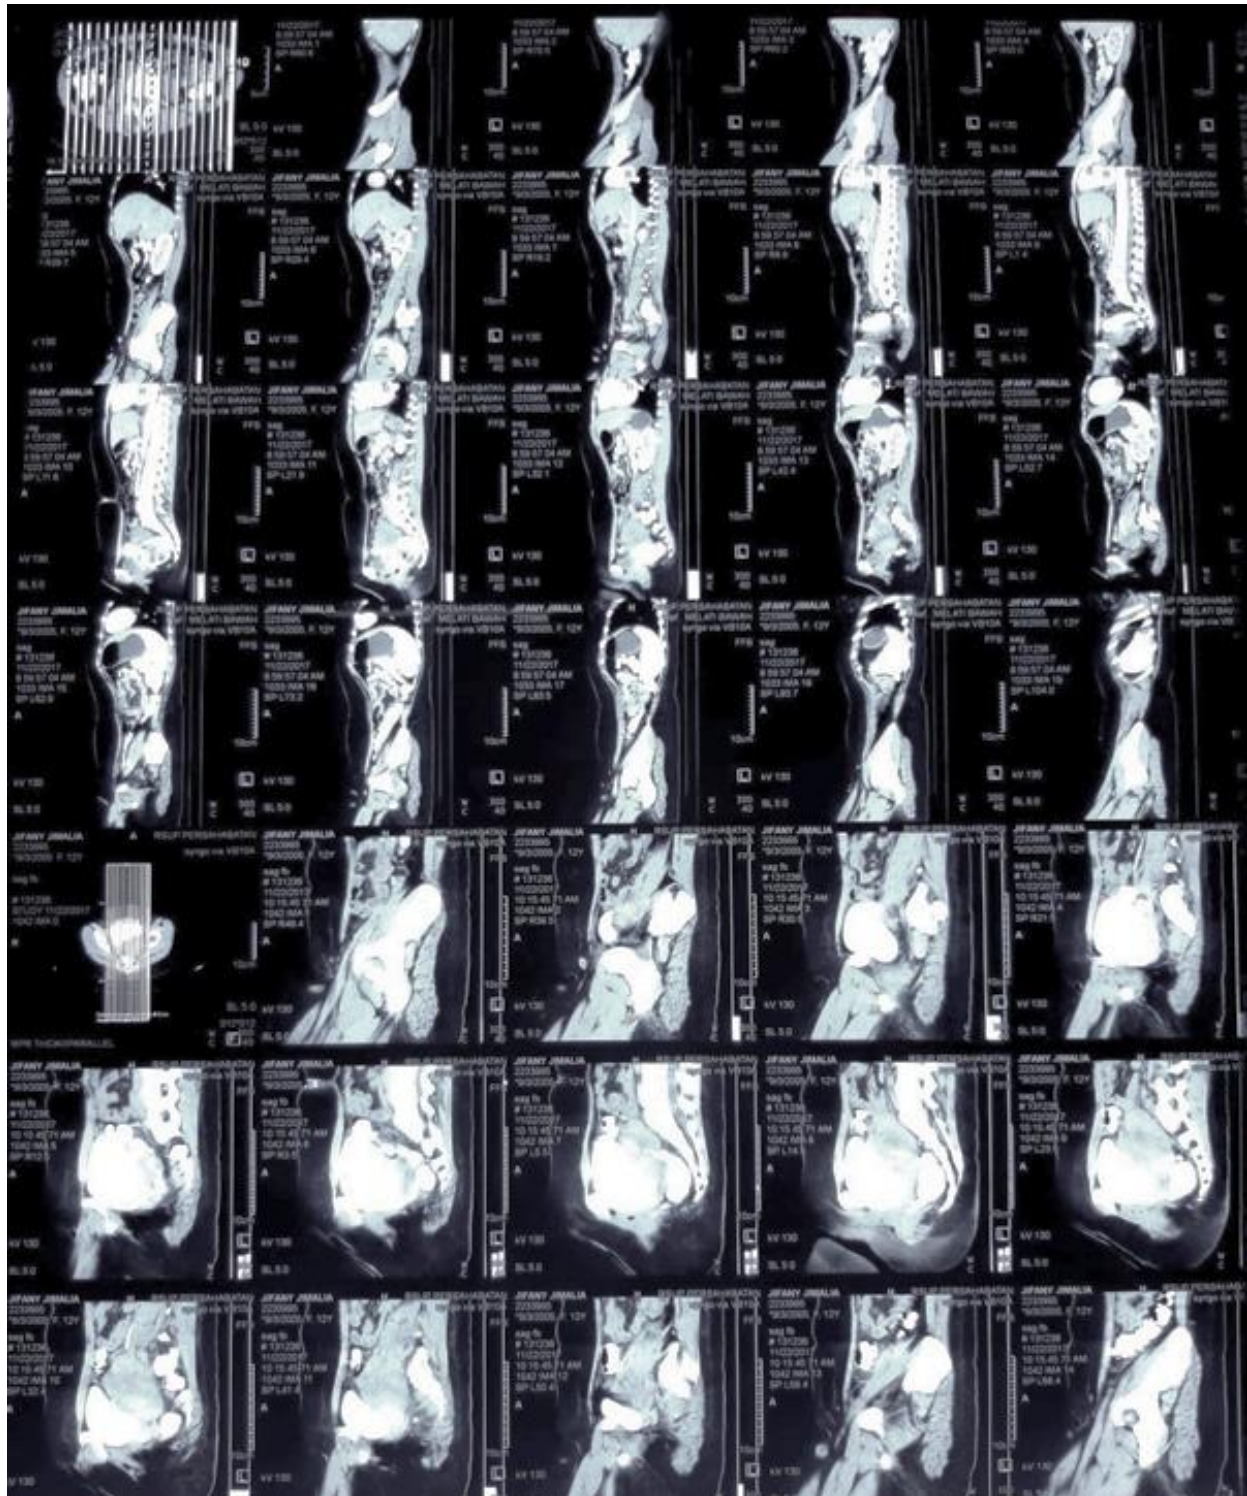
Sagittal sections of contrast CT scan.
